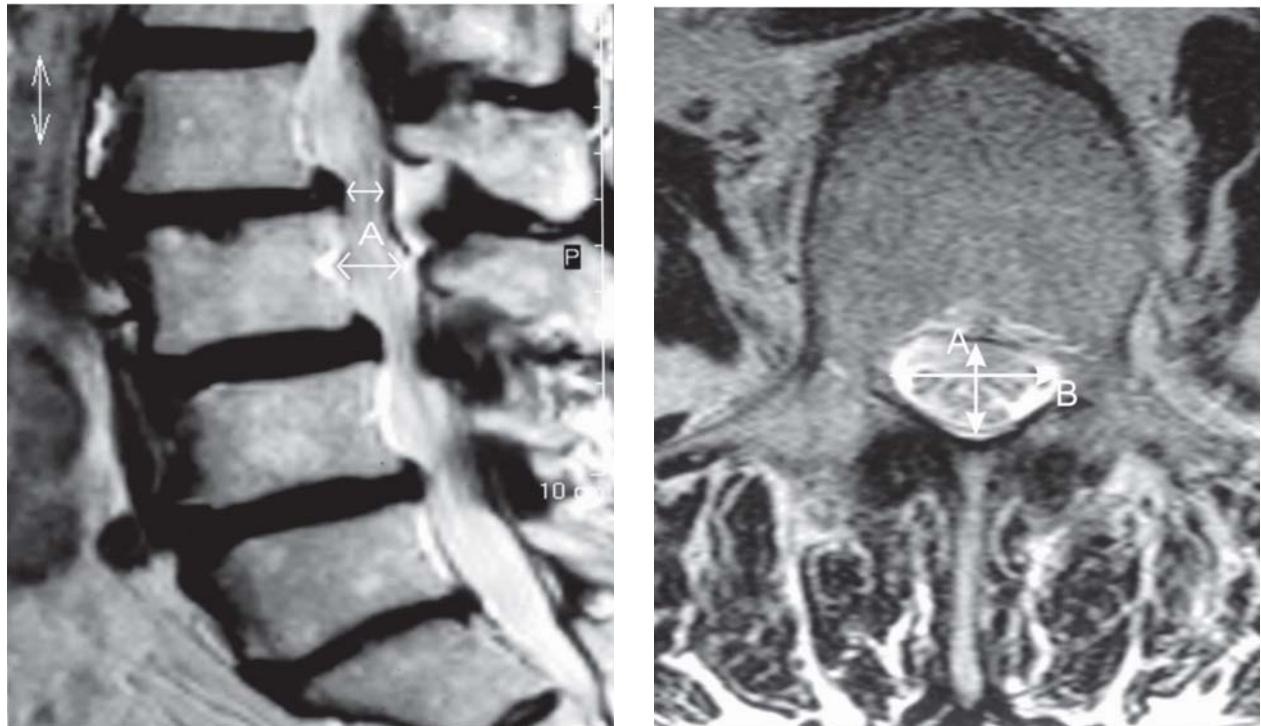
Sagittal and axial T2 weighted MR image of the lumbar spine showing sagittal spinal canal diameter (A), and antero-posterior (A) and transverse dimensions (B) that are used for calculating the cross sectional area of the spinal canal (Yukawa et al., 2002 (5)).
